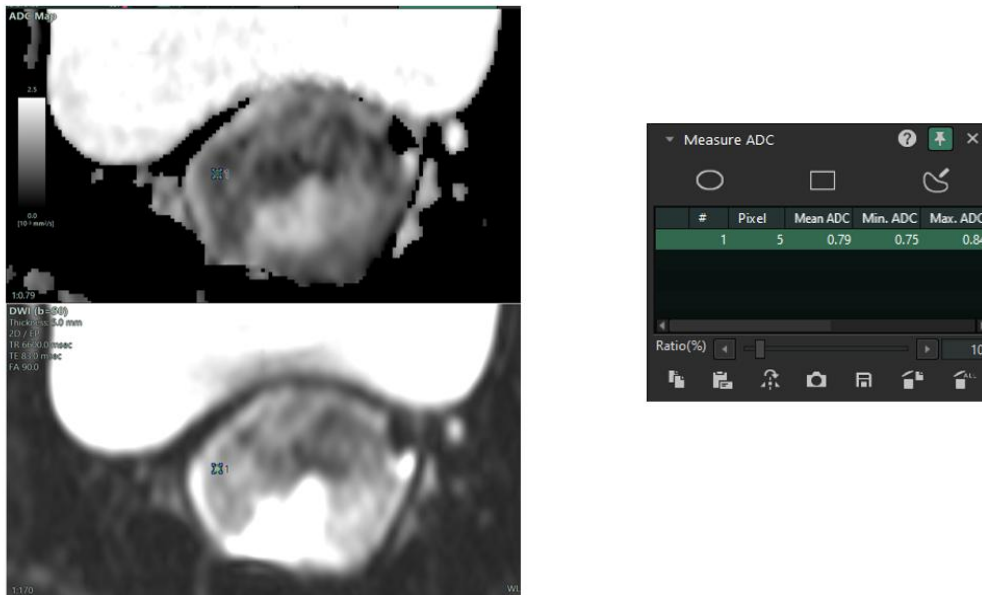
A patient with carcinoma cervix (pre-treatment) shows the DWI (b=50) and corresponding ADC image in a patient with a ROI of 5 pixel (1.3 mm) showing mean ADC of 0.79.
